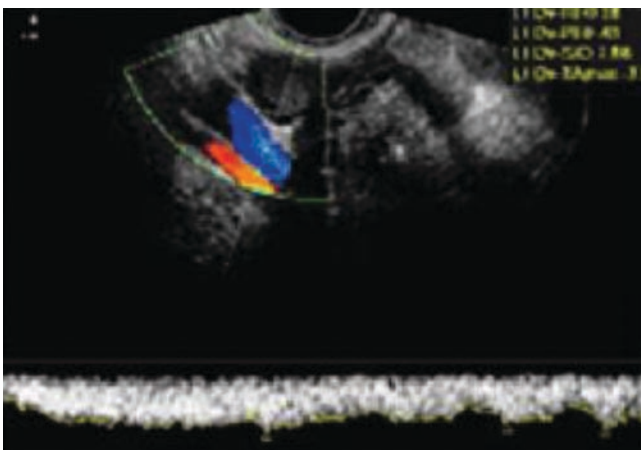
Color Doppler flow image and spectrum of the internal iliac vein
